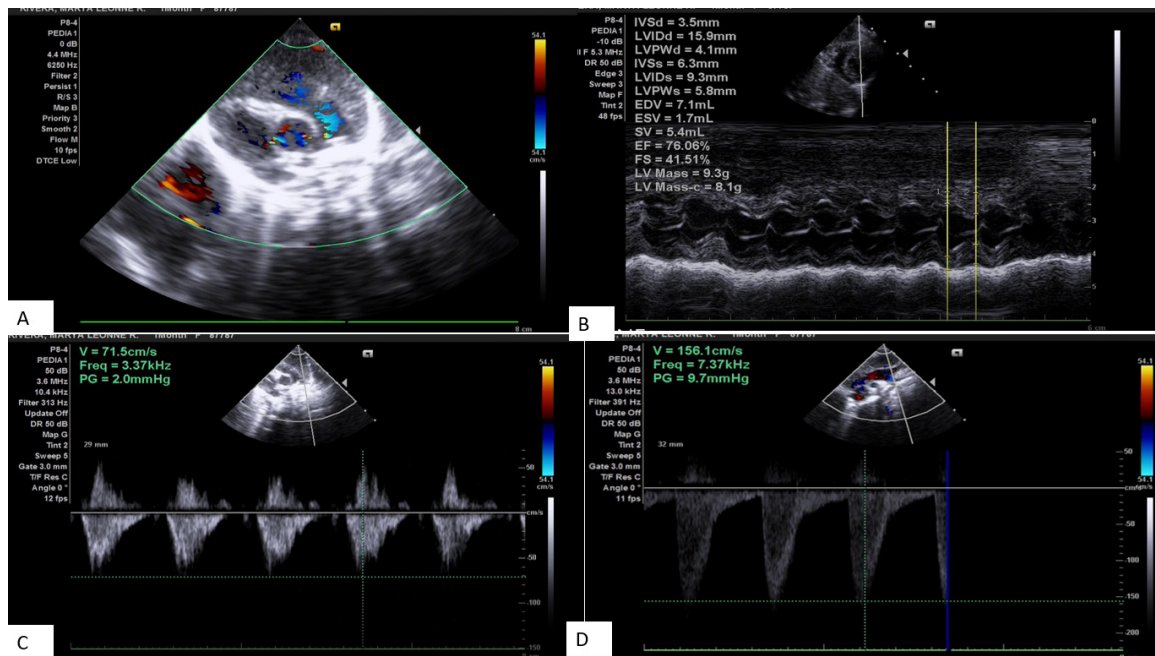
Transthoracic echocardiography images 1 month after percutaneous closure of PDA. Pictures A shows device in place and no leak. Picture B shows a decreased in LVED at 1.6cm (from 1.8cm pre device closure). Pictures C shows no gradient at the peripheral pulmonary artery while picture D showed a gradient of 10 mmHg at the descending aorta.
